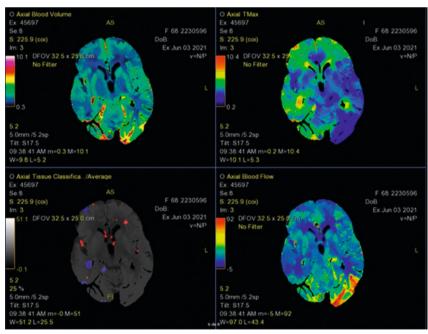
Perfusion computed tomography of the patient during her evaluation in the emergency department. Hyperperfusion pattern is observed in the left parieto-occipital region with increased cerebral blood flow (lower right), increased cerebral blood volume (upper left) and shortened mean transit time (upper right).
